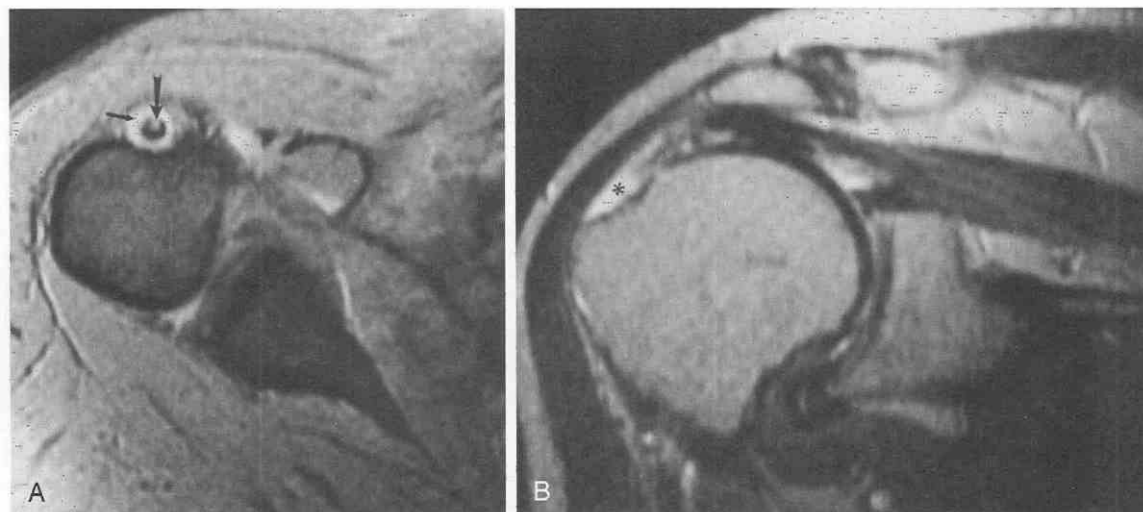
Bicipital tendinopathy. *A*, T2-weighted axial image. Fluid surrounds the bicipital tendon within the groove. In addition, an abnormal focus of high signal intensity is present within the tendon (*arrow*). The anterolateral branch of the anterior circumflex humeral artery may be identified (*small arrow*). *B*, T2-weighted coronal oblique image. In this patient, as is commonly the case, biceps tendinopathy is associated with rotator cuff disease. A large tendon gap (*asterisk*) marks the location of a full-thickness tear of the supraspinatus muscle and tendon. (Courtesy of Timothy Greenan, M.D., Washington, DC.)
